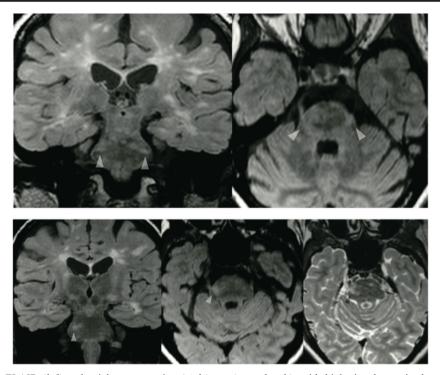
Top: Coronal  $T_2$  FLAIR (*left*) and axial reconstruction (*right*) showing bilateral hyperintense lesions in the trigeminal root entry zones and tracts (*arrowheads*), with increased signal in the transcisternal parts of the nerves. Bottom Coronal  $T_2$  FLAIR (*left*), axial reconstruction (*middle*) and the corresponding axial  $T_2$  TSE axial reconstruction (*right*) showing a hyperintense lesion in the trigeminal root entry zone
